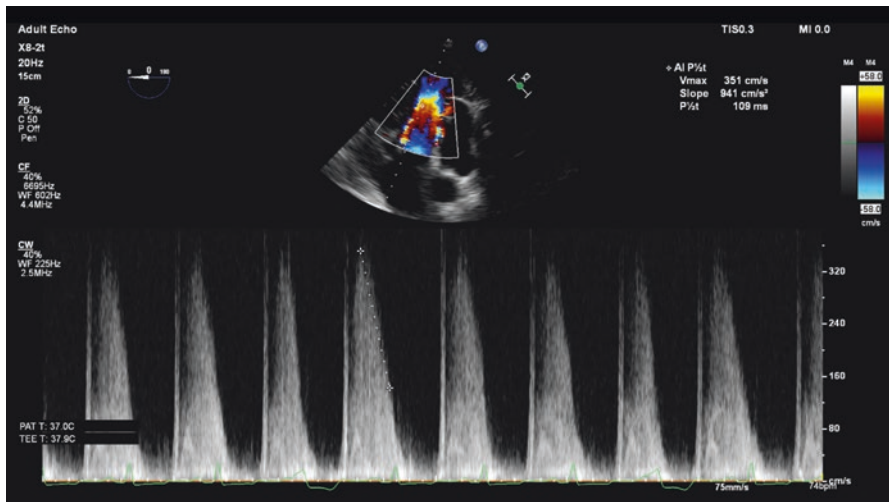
Pressure half-time through the aortic valve. In this patient, the steep curve indicates rapid equalization of chamber pressures suggesting severe AI. Also note that CFD was used to guide proper spectral Doppler alignment
